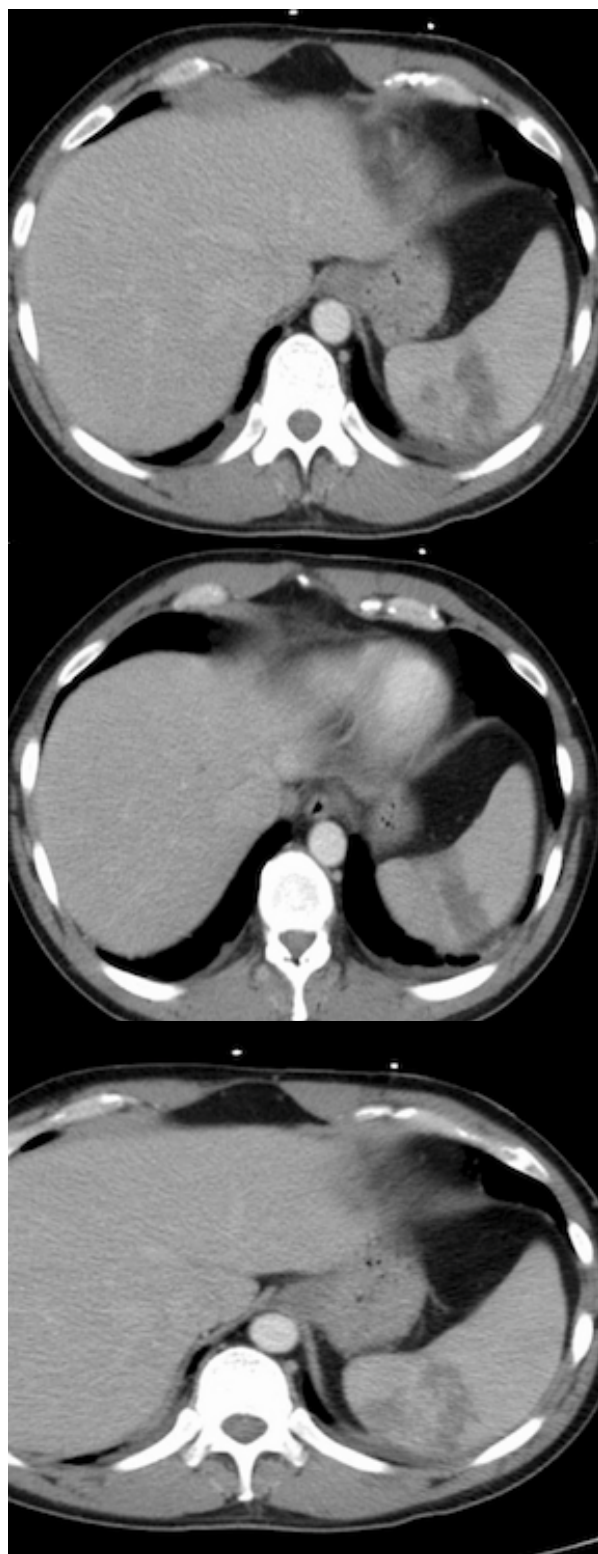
CT-scan Abdomen: Multiple splenic infarcts.
